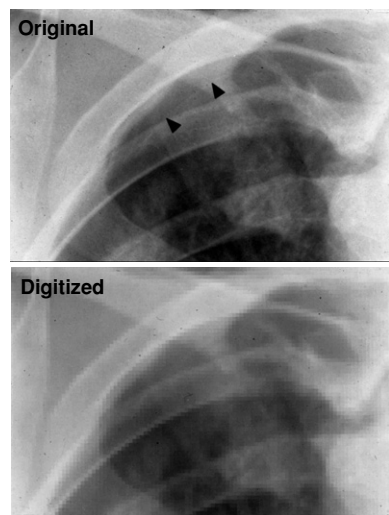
Comparison of an original chest radiograph with a subtle pneumothorax and the digitized image with a pixel size of 1.0 mm.
